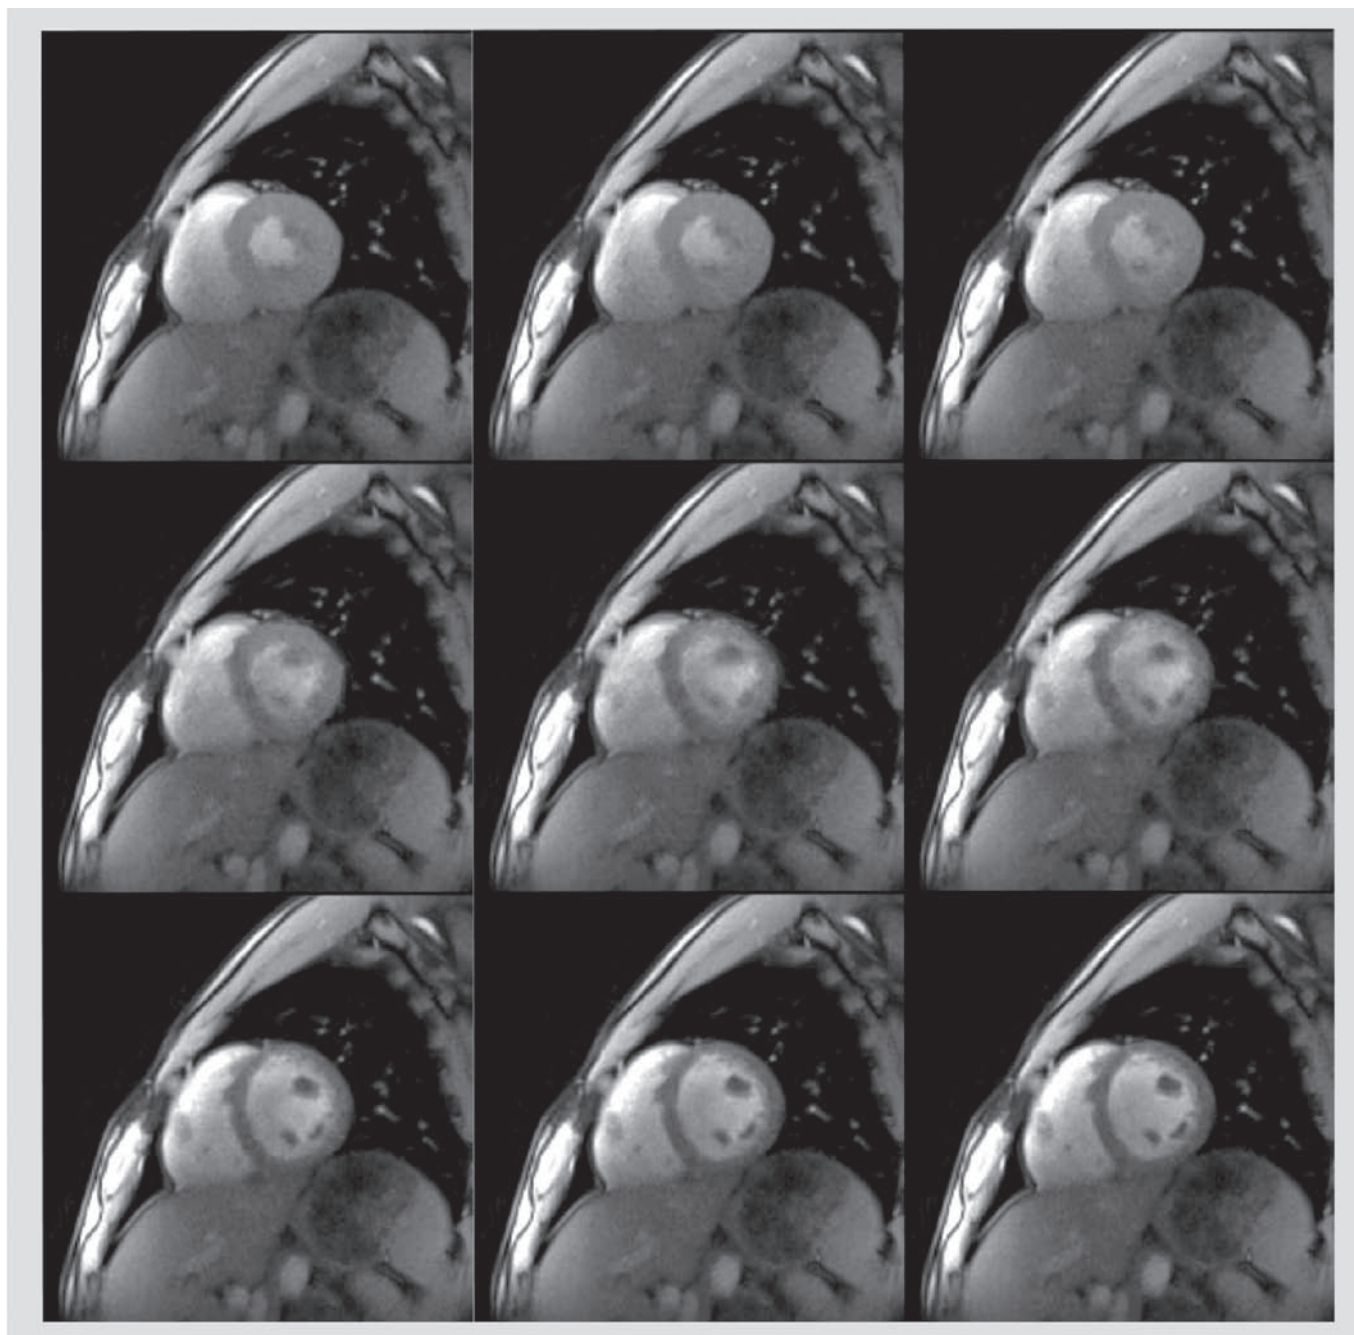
Real-time MRI of the human heart in a short-axis view. Consecutive frames (top left to bottom right) from a respective movie at 34 ms temporal resolution (30 fps) acquired using radial fast low-angle shot (15 spokes, repetition time/echo time = 2.28/1.46 ms, flip angle 8°, $1.5 \times 1.5 \times 6.0$ mm³). The images represent a 373-ms period of a single cardiac cycle from peak systole (top left) to early diastole (bottom right) demonstrating the rapid post-systolic expansion of the contracted and thickened myocardium. See also SUPPLEMENTARY MOVIE 3.
